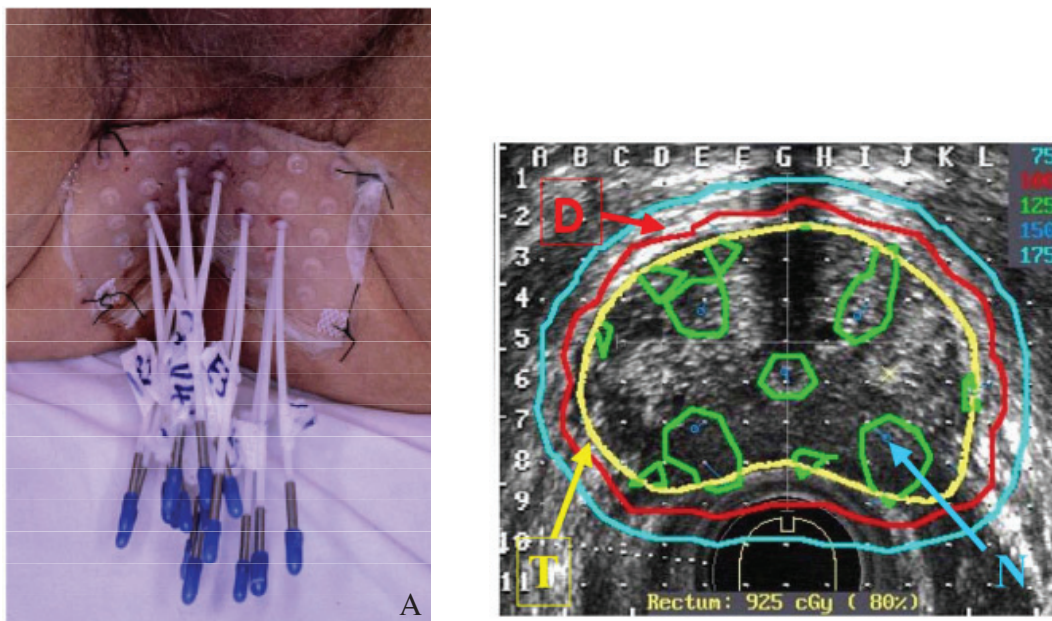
High-dose-rate interstitial brachytherapy for prostate cancer (intermediate-to high-risk group) a) transperineal plastic catheter implantations; (from Moule RN, Hoskin PJ. Non-surgical treatment of localised prostate cancer. *Surgical Oncology* 2009; 18: 255-267). b) axial ultrasound imaging showing the prostate gland (yellow). The prescribed dose (100%), shown by the red line, correlated with needles (light blue points) (from: Kovacs G, Pötter R, Loch T, et al. GEC/ESTRO/EAU recommendations on temporary brachytherapy using stepping sources for localized prostate cancer. *Radiother Oncol* 2005; 74: 137-148)
